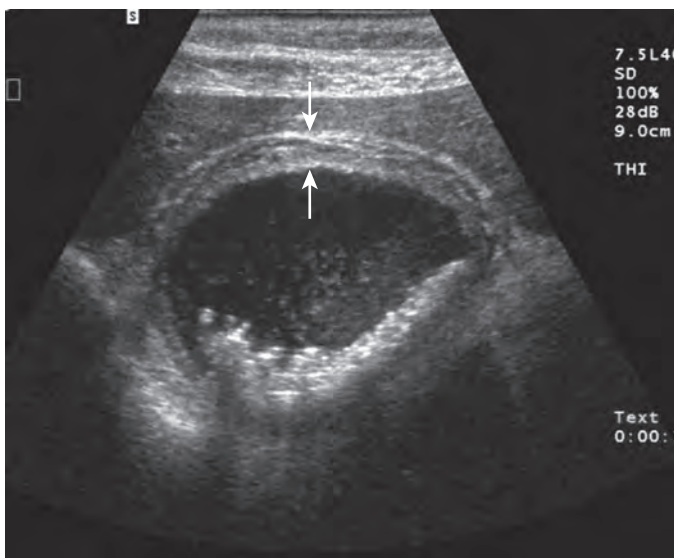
Acute cholecystitis: sonographic features.
